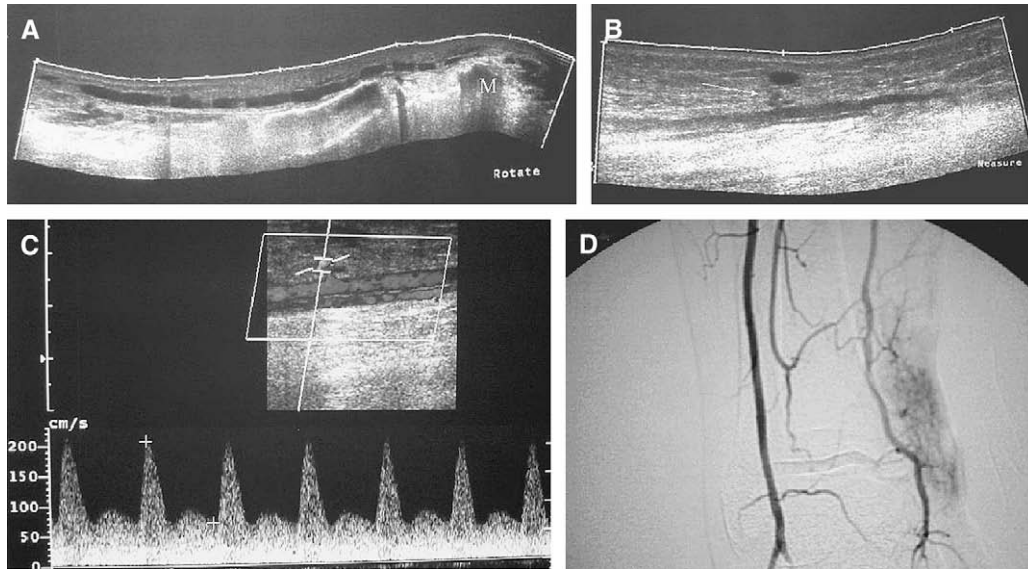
A 43-year-old man with cellulitis. (A) Subcutaneous oedema originating at the level of medial malleolus is seen up to the level of one third of the distal cruris. (B) A tibialis posterior branch (arrow) feeding the inflamed area at the level of the midcruris. (C) Spectral Doppler imaging showing high volume flow within the arterial structure. (D) Late arterial phase of angiography planned to exclude arteriovenous malformation confirms the EFOV findings.
